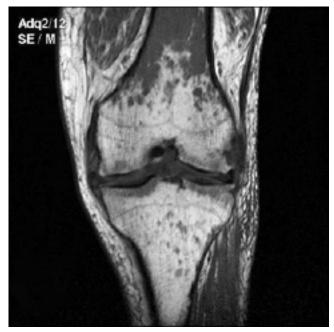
Coronal MRI of the left knee in a patient with chronic myelomonocytic leukemia, showing diffuse infiltration of bone marrow in femur and tibia. Multiple coalescent hypointense nodules in T1 sequence (A) and hyperintense in fat-suppressed proton-density sequence (B) localized in metaphysis and epiphysis of femur and tibia.
